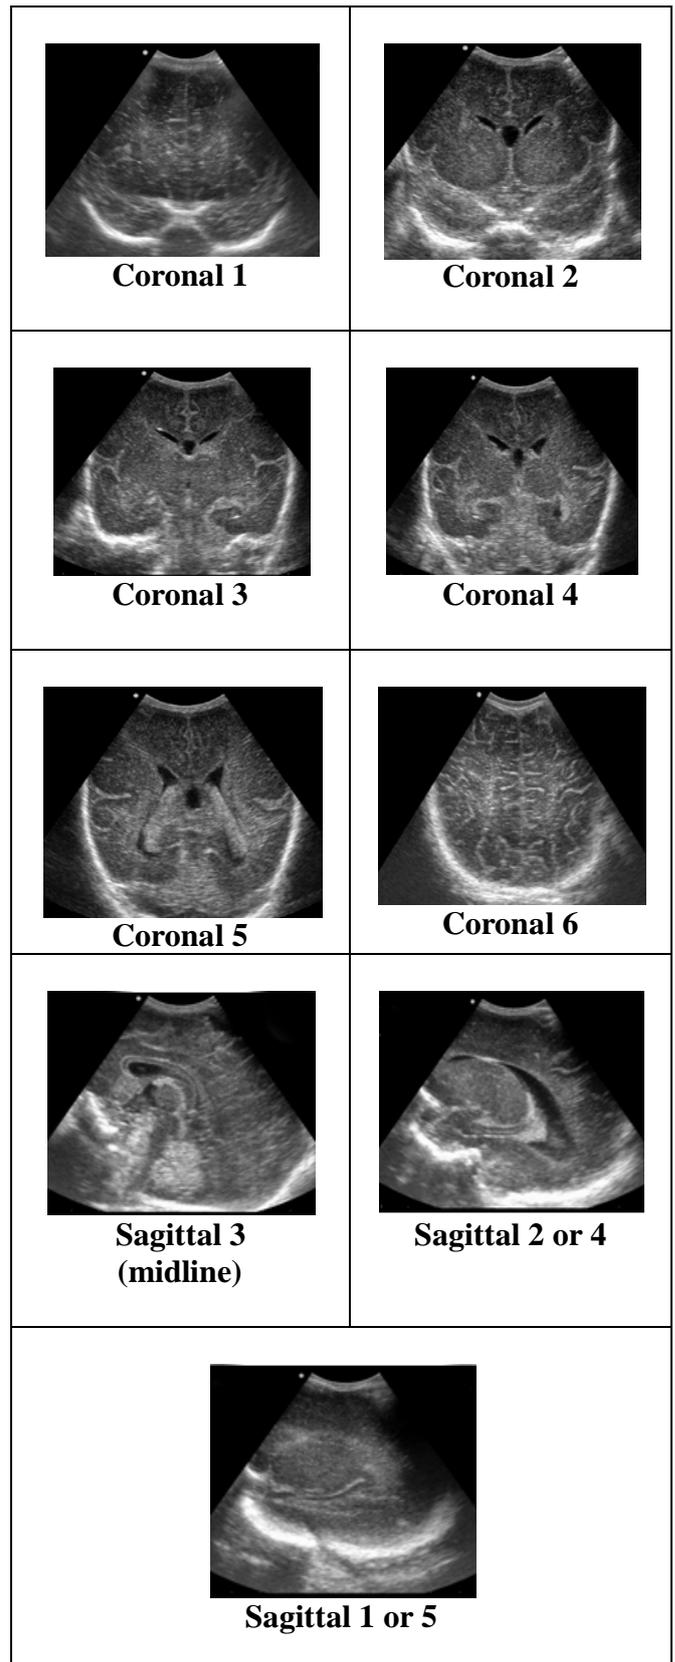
Neonatal Cranial Ultrasound: Coronal and sagittal planes, images obtained in the neonatal department of VUmc in a neonate of 29+6 (coronal 2-5 and sagittal) and 40+3 (coronal 1 and 6) gestational weeks.
